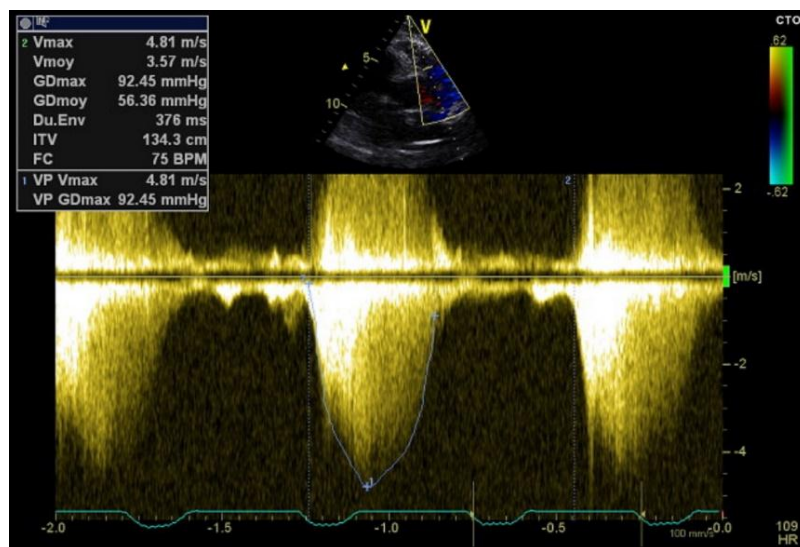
Continuous wave Doppler showing the pulmonary stenosis flow.
